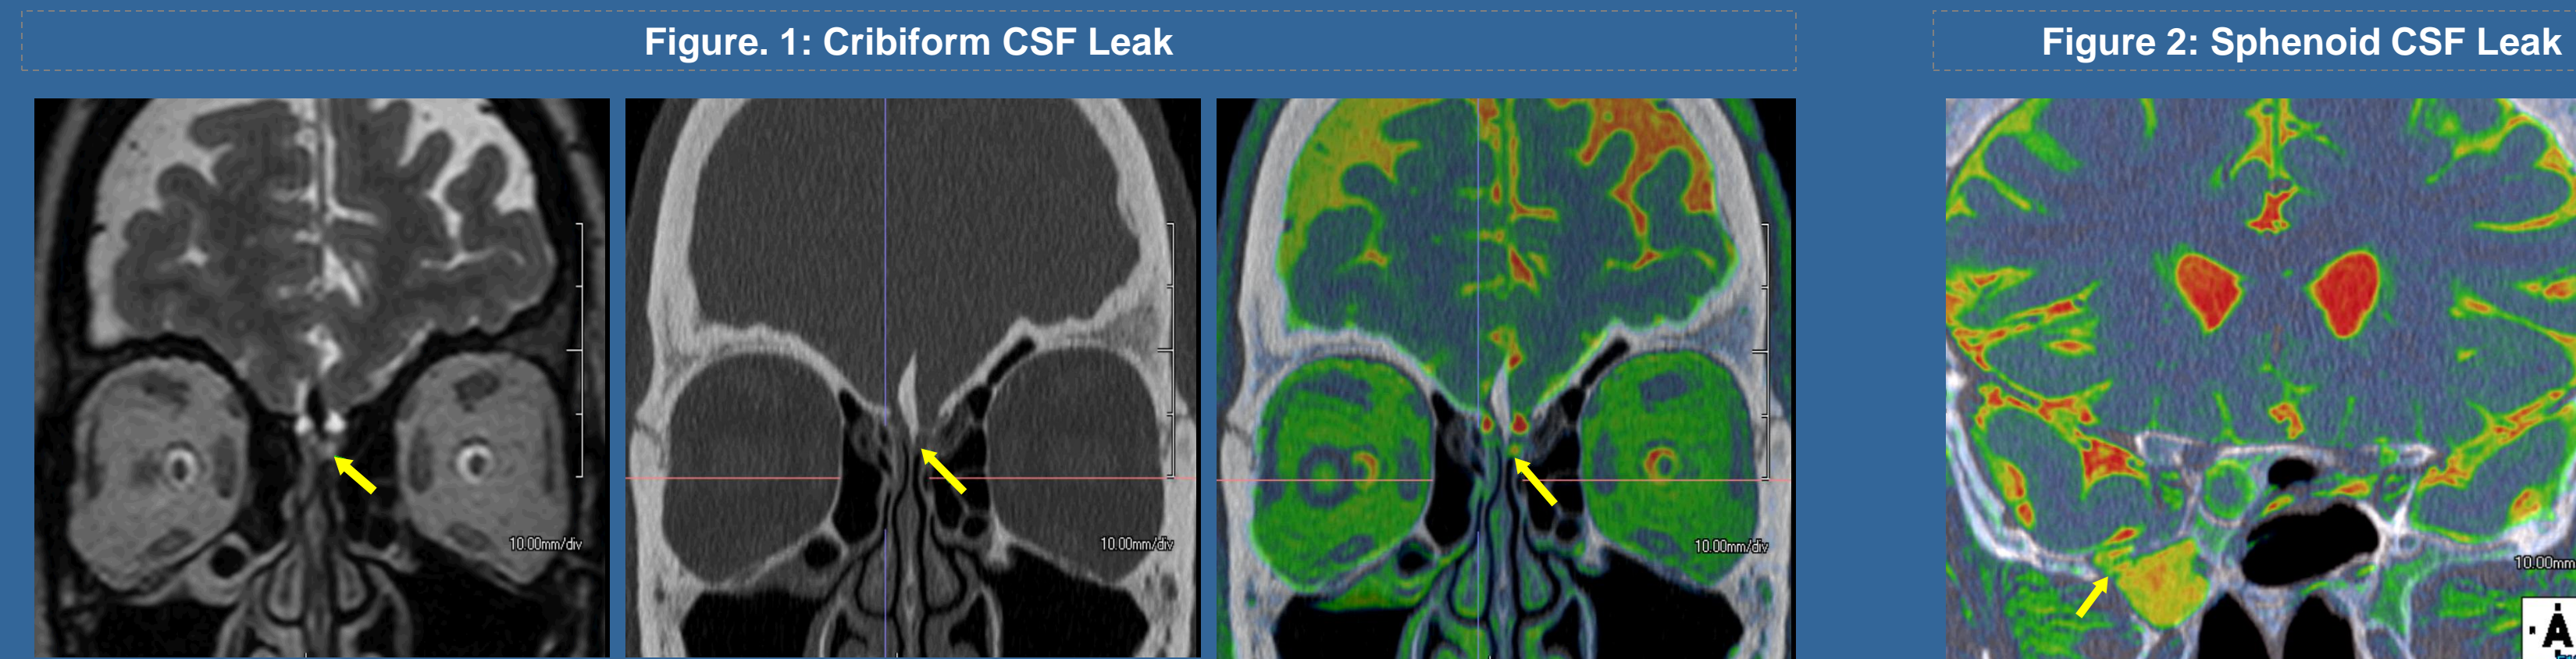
Cribiform CSF leak. Coronal T2 image (A) reveals asymmetric high signal in the left olfactory recess (arrow), which is not present on the right. CT (B) demonstrates intermediate density corresponding to this fluid. The olfactory groove is also wider on this side. Fused CT-MR image (C, with CT in grayscale and T2 in color) clearly shows site of fluid (arrow) relative to bony landmarks.
